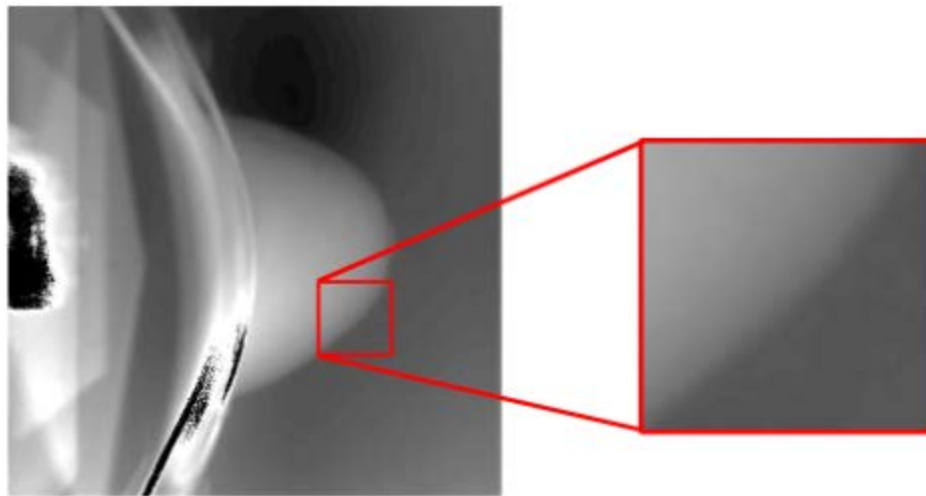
The results of a captured plane radiographic image. (a) Raw digital radiographic images exported from Simulix Evolution<sup>TM</sup> (Nucletron BV, Veenendaal, The Netherlands) console computer. (b) Result of (a) being processed through a “minus logarithm” to compensate for the intensity variation of radiation from the source, to minimize the background noise, and with the gray level inverted. (c) Result of (b) being filtered by a 2-D  $10 \times 10$  Wiener low-pass filter to reduce the constant power additive noise.
